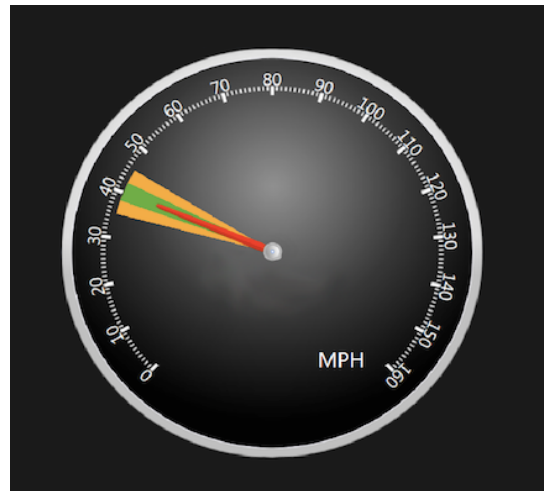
Initial interface mock-up based upon ideas emerging from the DWI workshop.
